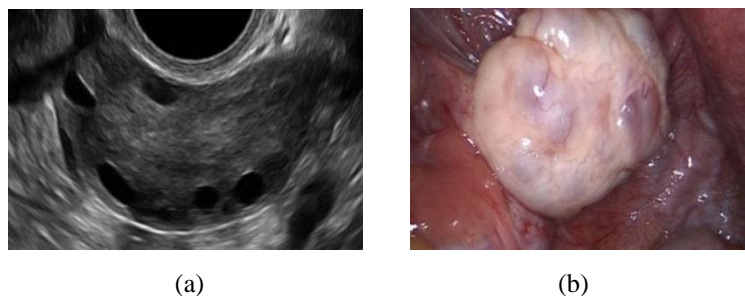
12: Represents ultrasound image of a normal ovary with its corresponding laparoscopic view (a) Ultrasound image of the normal left ovary (b) Laparoscopic view of the normal left ovary
